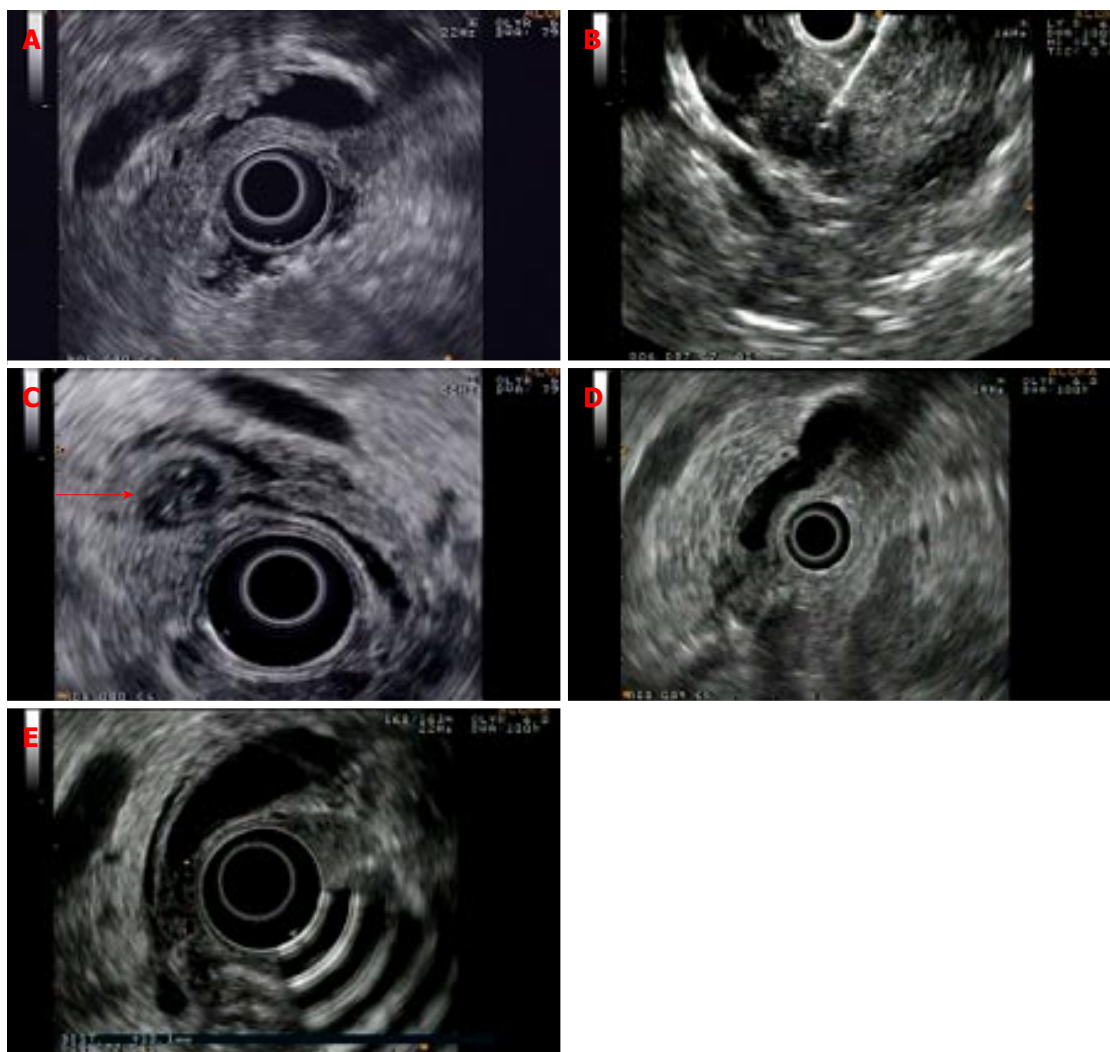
Examples of pathologic findings identified on endoscopic ultrasound in patients with negative prior imaging tests. A: Choledocholithiasis: Small stones in the common bile duct; B: Small pancreatic cancer; C: Small duodenal diverticulum with bile duct indentation (see arrow); D: Ampullary carcinoma with pancreas invasion; E: Inflammatory thickening of the distal common bile duct.
